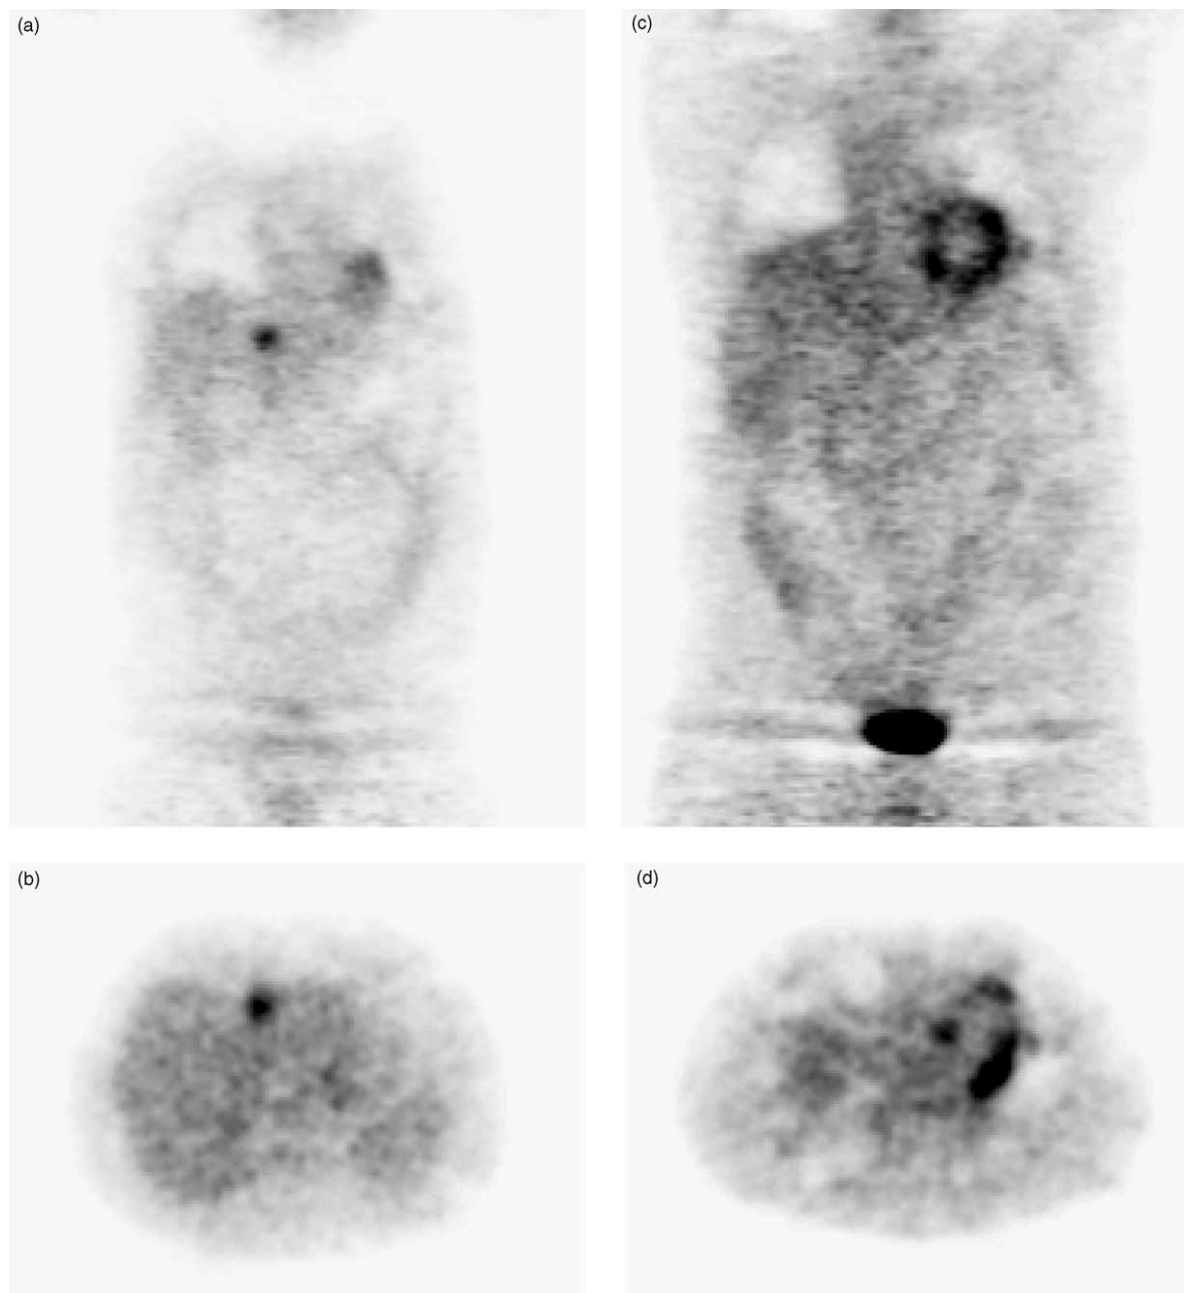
PET scan in a 69-year-old patient with a previous history of colon cancer. A routine follow-up liver ultrasound had indicated a suspicious lesion, but the spiral CT was negative. PET confirmed the presence of a liver metastasis (a and b) and also showed a small lesion in the left lung, next to the heart (c and d).
